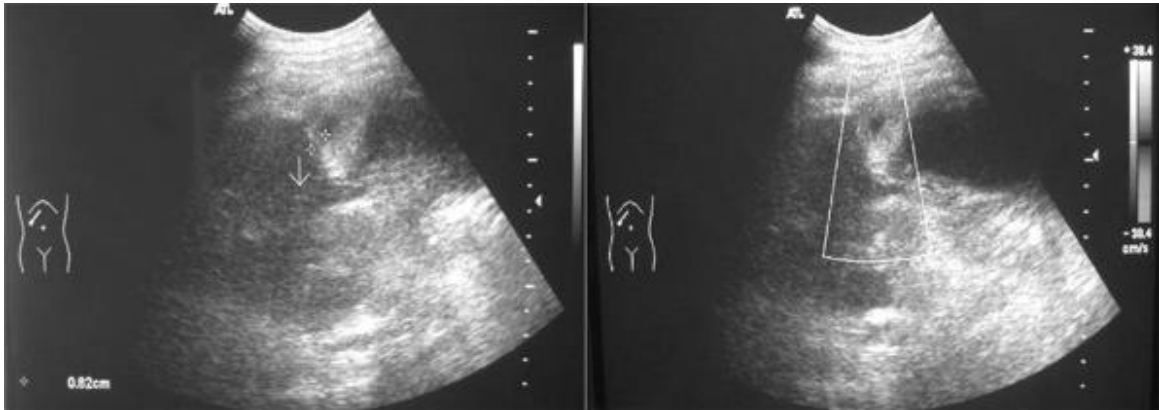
Abdominal ultrasound showing the gallbladder with thickened wall and a hyperechoic image suggesting the torsed mesentery. The US Doppler shows no flow within the gallbladder. ⁽⁷⁾
